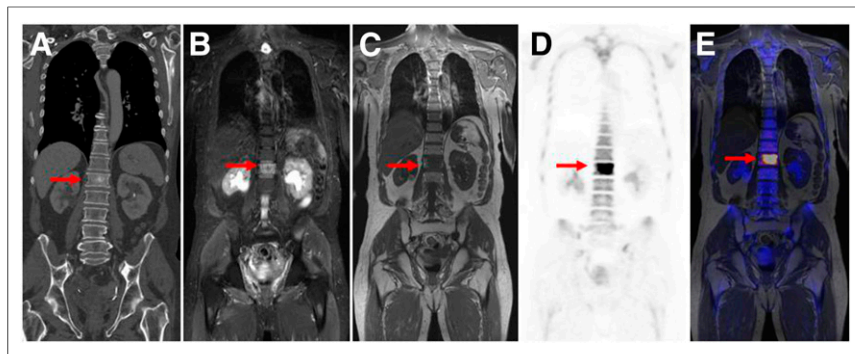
CT and ^{18}F -fluoride PET/MR images of 64-y-old patient with prostate cancer and bone metastases with coronal CT images (A, arrow), coronal T2 short τ inversion recovery (B, arrow), and T1 TSE (C, arrow). PET of PET/MR shows intense focal ^{18}F -fluoride uptake (D, arrow) whereas fused ^{18}F -fluoride PET image with simultaneously acquired T1 TSE image (E) demonstrates concordance of metabolic and anatomic imaging.
